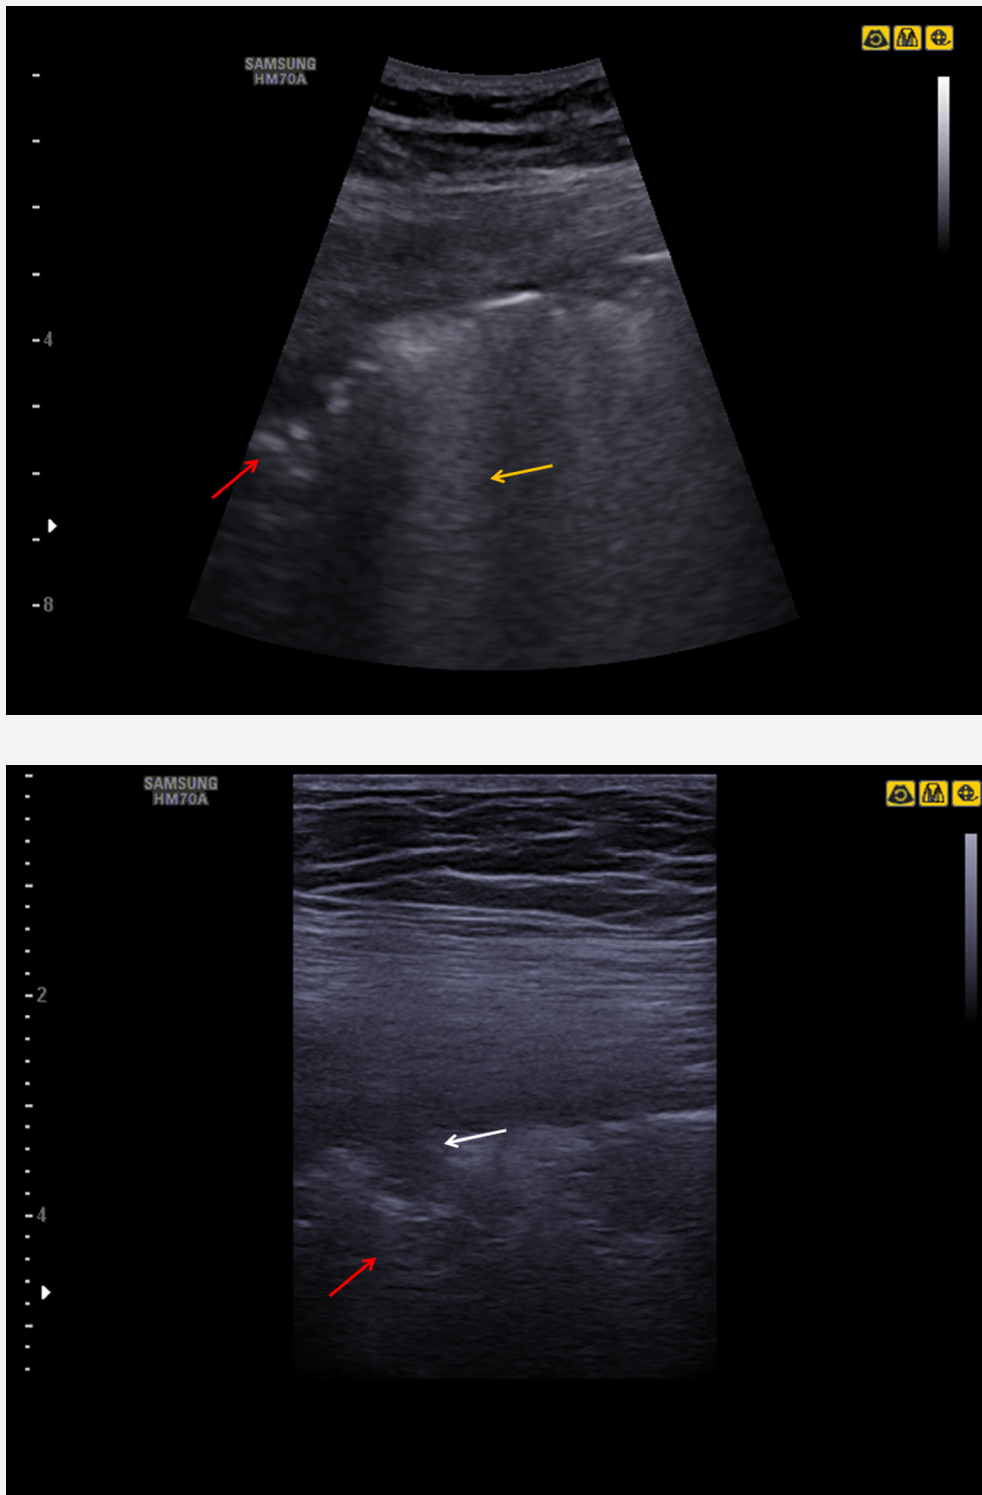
Lung ultrasound using the Samsung HM70A.
